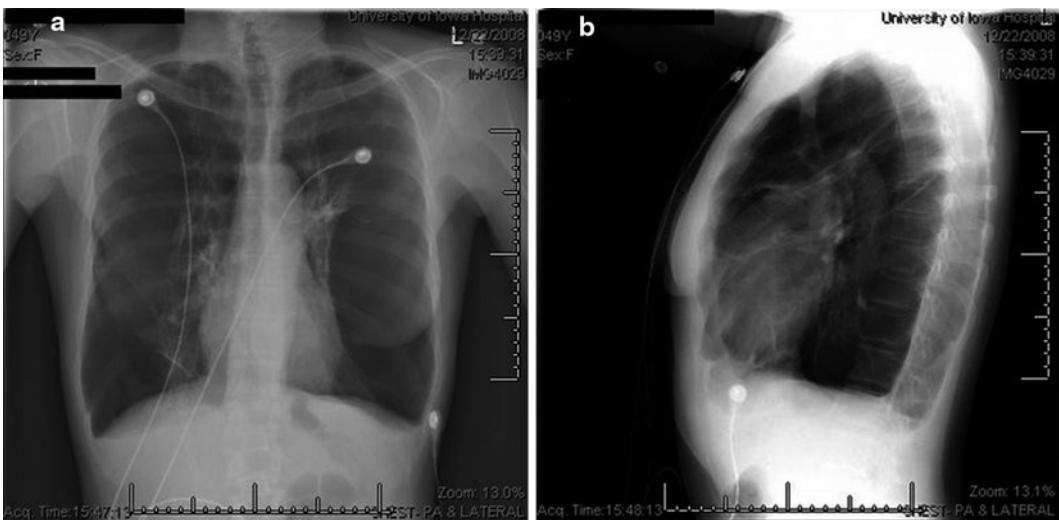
(a) A posterior–anterior chest X-ray of a patient with a bulla in the left hemithorax. (b) The same patient on the lateral radiograph.
